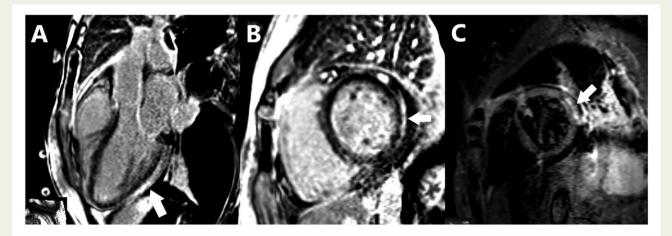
Cardiac magnetic resonance images. (A) Three-chamber late gadolinium enhancement view showing infero-lateral subepicardial enhancement (white arrow); (B) short-axis late gadolinium enhancement mid-cavity view showing the same area of infero-lateral subepicardial enhancement (white arrow); (C) T2-weighted short-tau inversion recovery sequence showing a short-axis mid-cavity view with enhanced signal (oedema) of the subepicardial infero-lateral wall (white arrow).
